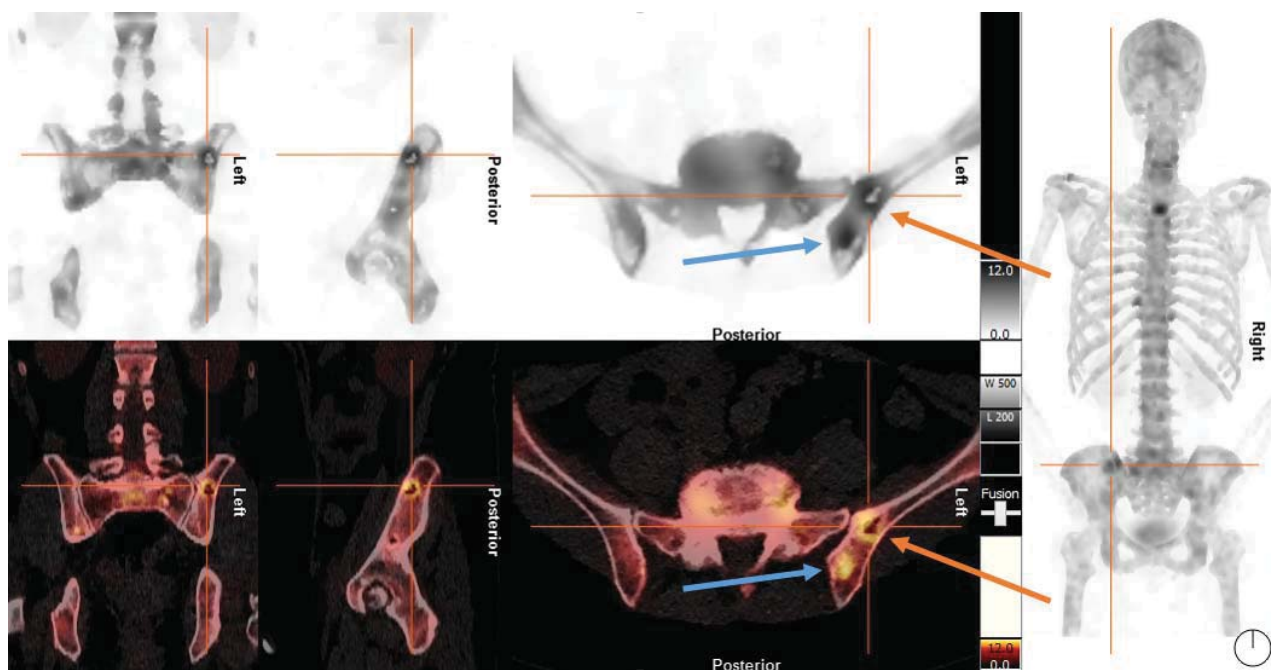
Case 4: SPECT images and SPECT/CT (Blue arrows = osteoblastic metastasis and orange arrows = osteoclastic metastasis)
